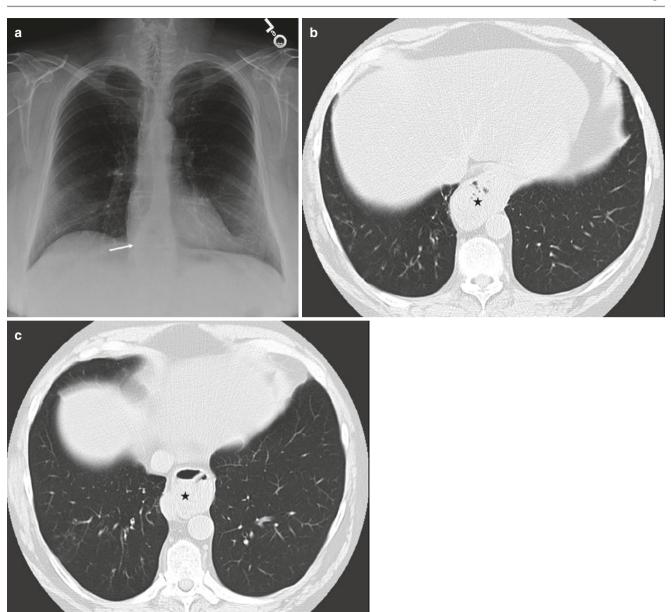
Mild changes of recurrent aspiration. (a) Frontal chest radiograph shows a retrocardiac opacity displacing the azygo-esophageal recess (arrow). (b, c) Axial CT images show moderate size hiatal hernia
